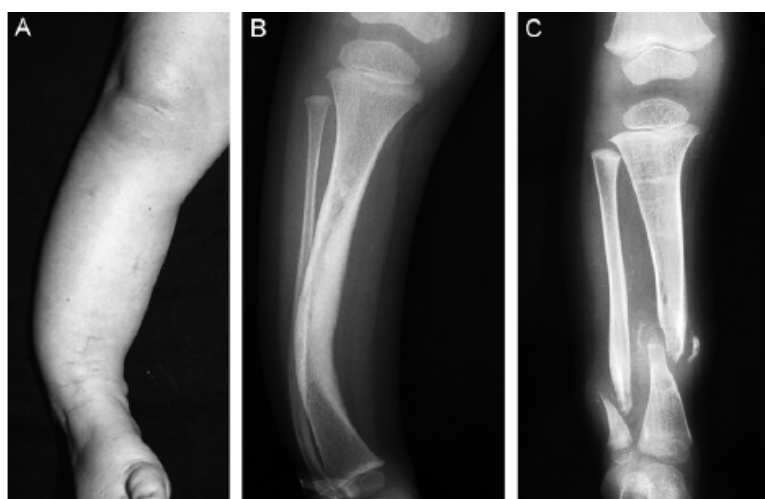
Clinical (A) and radiographic (B) heterogeneity of congenital pseudarthrosis of the tibia (CPT) with anterolateral bowing of the leg and atrophic pseudarthrosis of the lower third of the leg (C). Pannier S. Congenital pseudoarthrosis of the tibia. Orthopedics & Traumatology: Surgery & Research 2011; 97(7): 750–61.
